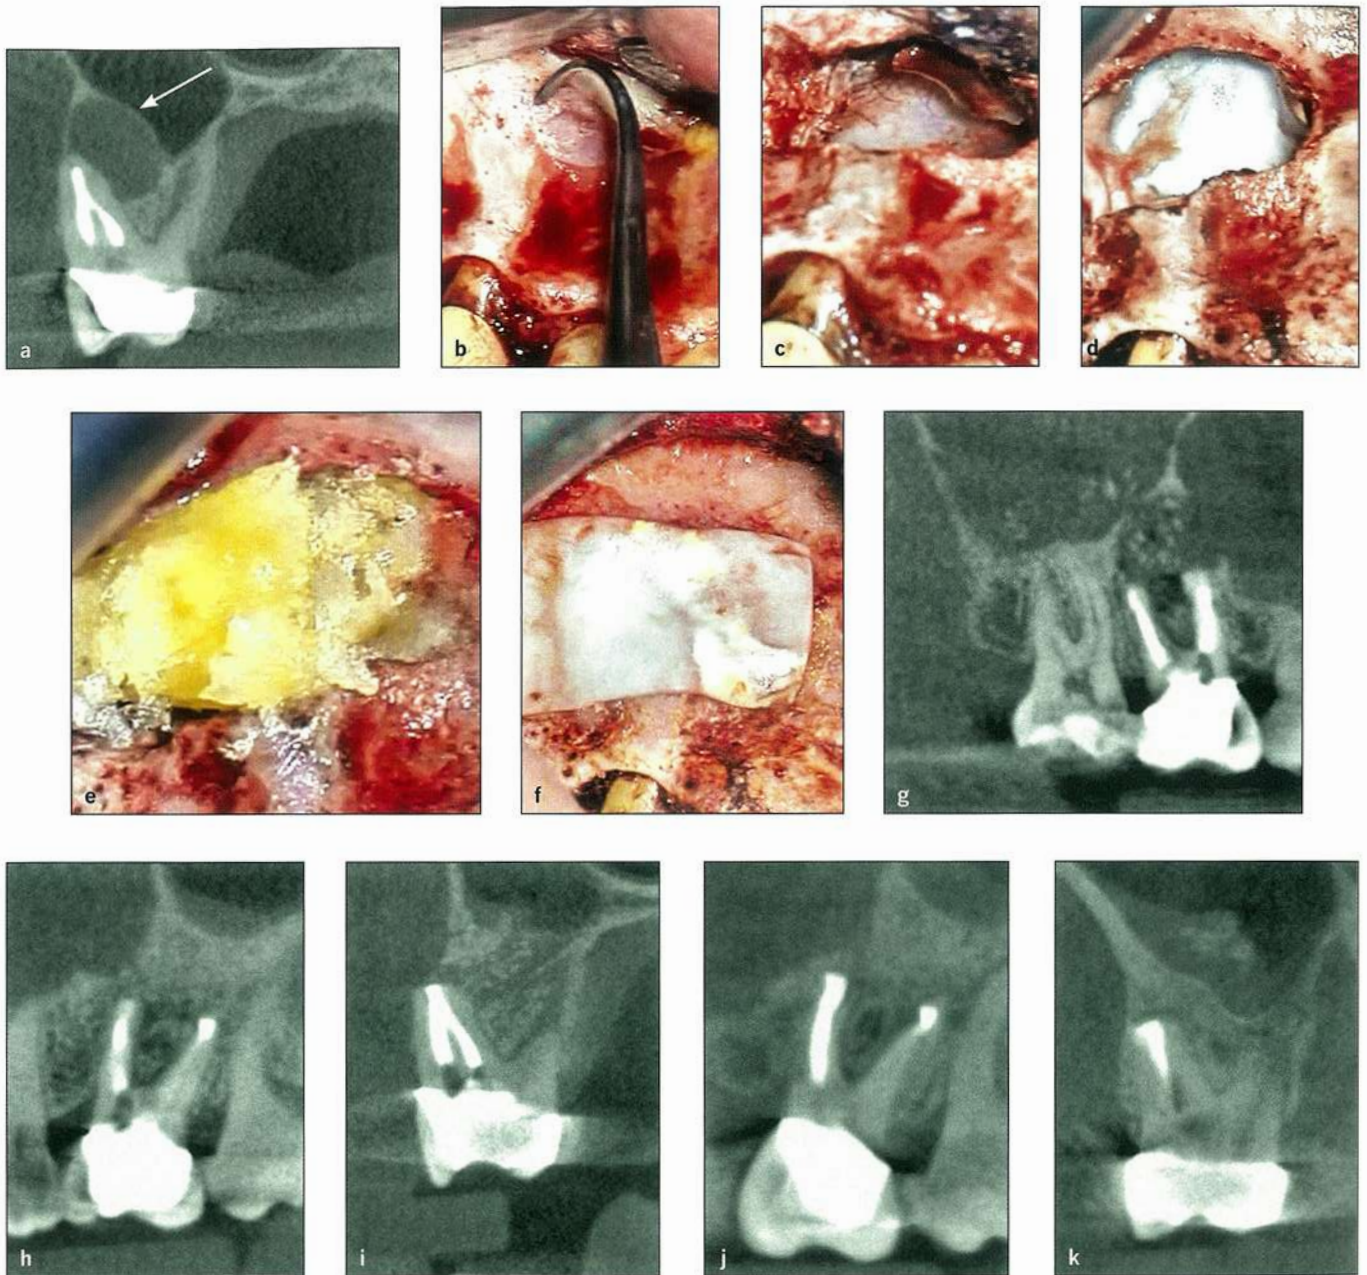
(a) Coronal view of the mesiobuccal root of a maxillary right first molar that presented for periapical surgery. Note the low-density lesion causing thinning of the lateral wall of the maxillary sinus (*white arrow*). (b) Clinical photograph demonstrating the porous and thin cortical plate that coincides with a periapical cyst. (c) Clinical photograph after degranulation of the lesion demonstrating the maxillary sinus exposure. The vascularity of the sinus and bony spicule can be noted. (d) The sinus perforation was covered with a CopiOs membrane. (e) Periapical defects grafted with Puros allograft material. (f) Grafted defect covered with a CopiOs membrane. (g) Immediate postoperative CBCT scan. (h and i) Sagittal and coronal CBCT views at the 1-year recall. (j and k) Sagittal and coronal CBCT views at the 2-year recall.
